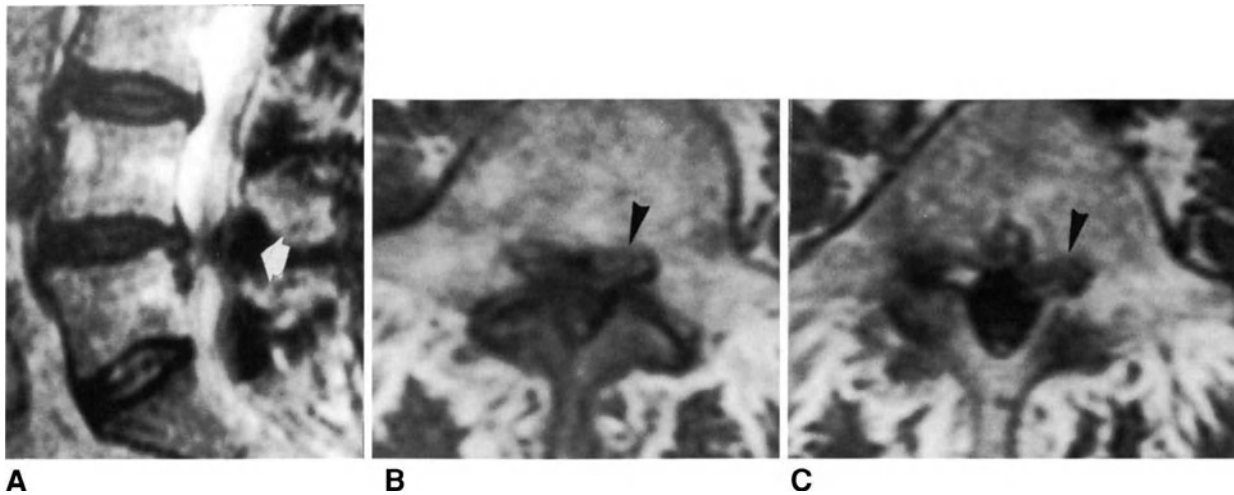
Left L4-L5 disc herniation associated with nerve-root canal stenosis. (A) Turbo spin-echo T2-weighted sagittal left paramedian image showing a subligamentous extruded L4-L5 disc herniation and posterior compression of the thecal sac by hypertrophic ligamentum flavum (arrow). (B) and (C) Spin-echo T1-weighted axial images showing the disc herniation on the left (arrowheads) and constriction of the nerve-root canal.
